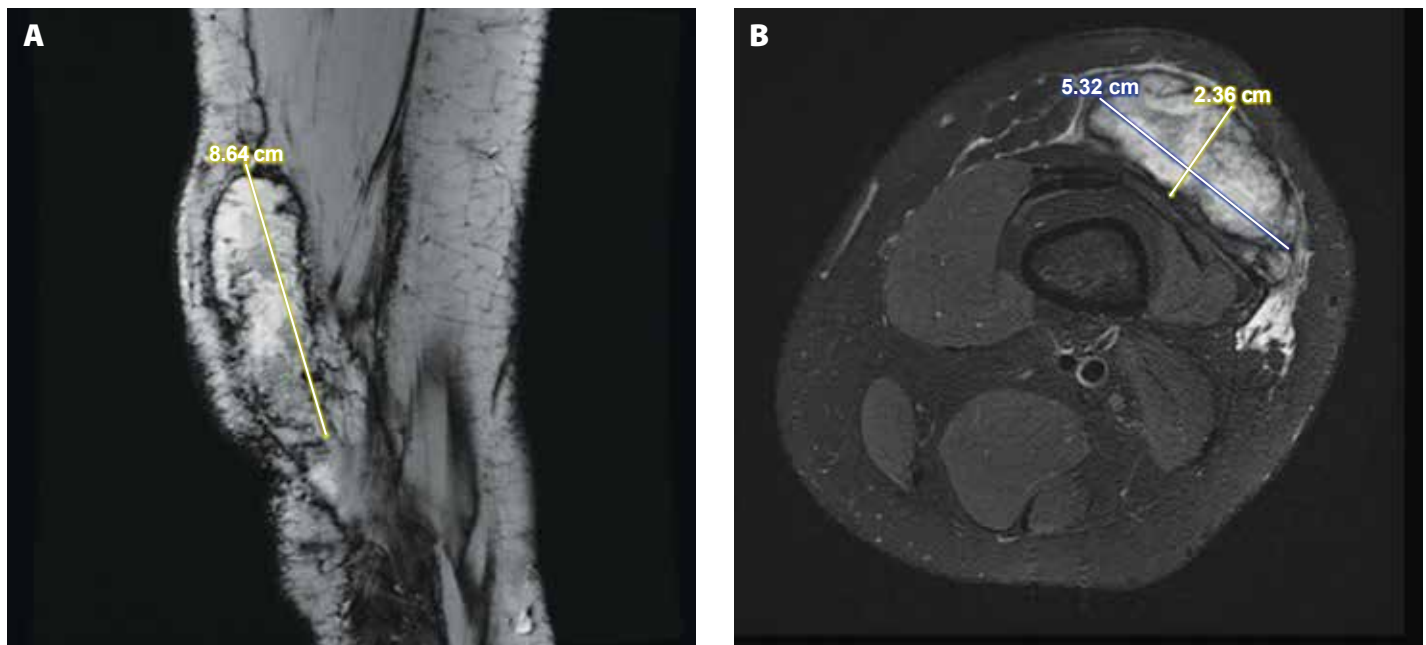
A: Sagittal T2 MRI view of the eumycetoma showing approximately 8.64 cm length in the anterolateral thigh. B: Axial T1 MRI displaying an approximately 5.32 × 2.36 cm cross-section of the lesion. The heterogeneous lobulated nature of the mass was demonstrated on these representative images.
